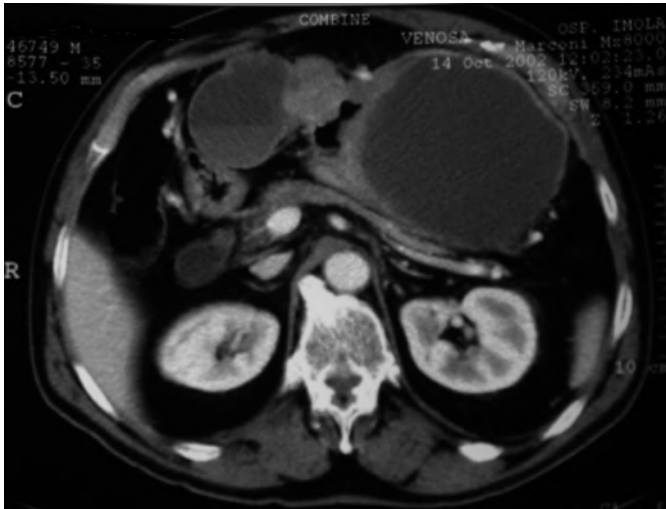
Abdomen Computed Tomography. A larger fluid filled pseudocyst (>20cm) is adjacent the greater gastric curvature and another smaller (7 cm) similar lesion with a solid area is adjacent lesser curvature.
